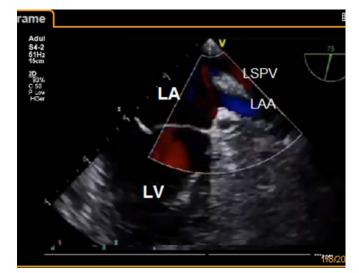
Transesophageal echocardiography. Midesophageal view at 75 degrees. Color Doppler shows red color inside LSPV.
